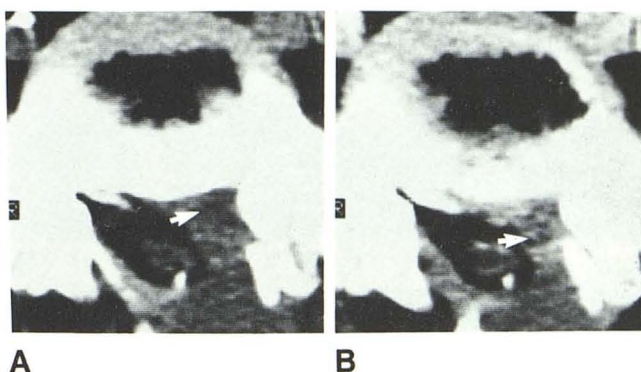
Nonenhancing epidural fat. A, Preenhancement CT scan. Soft tissue in left recess has low density and represents epidural fat within scar (*arrow*). B, After enhancement. Lucency of fat (*arrow*) presiding between enhanced tissue should not be mistaken for nonenhancing disk fragment. Disk material is usually of considerably higher density in nonenhanced CT section.
